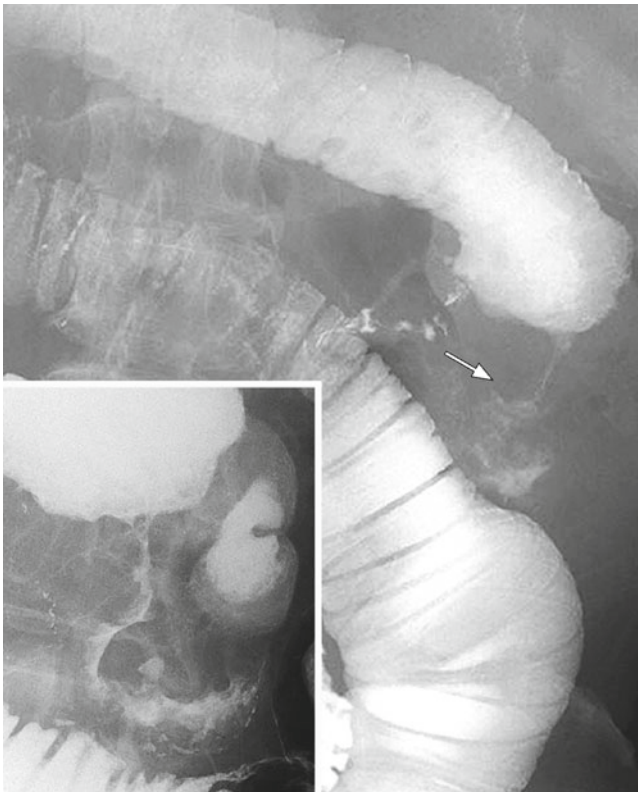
Radiography revealed long luminal narrowing with complex flexion and dilation of the intestine on the proximal side
